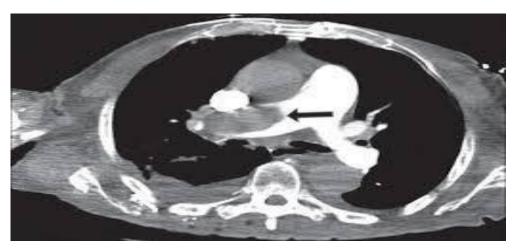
CT Pulmonary Angiography showing Rt pulmonary artery thrombus
